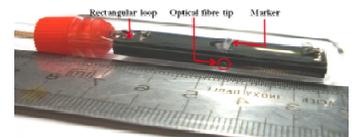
MRI-Optics endoluminal probe used during our experiments.
